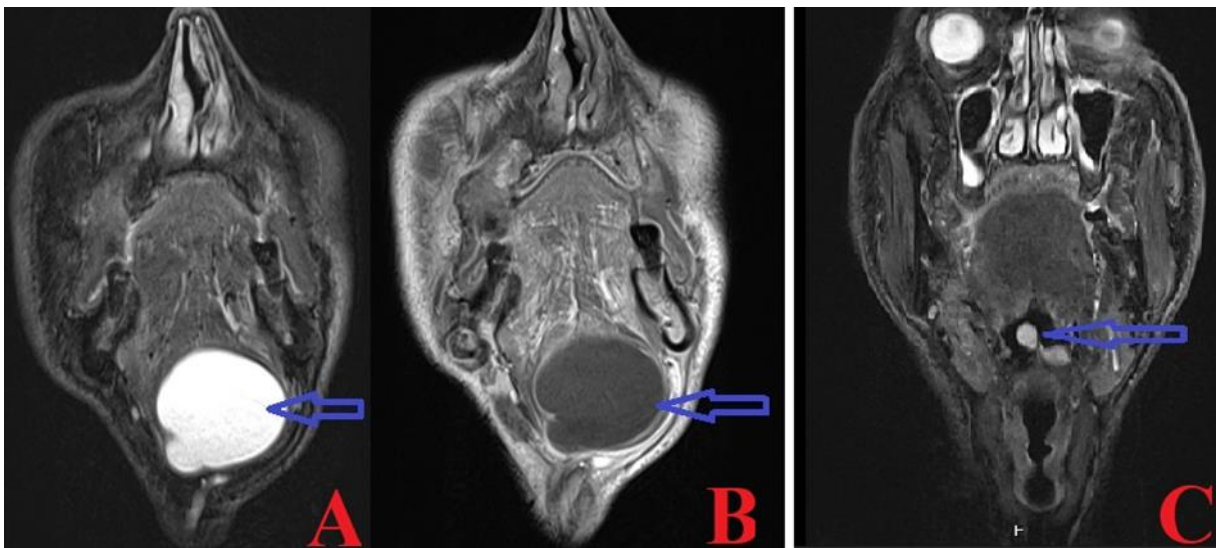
The coronal plane of the MRI shows a cystic mass (A, B) and valvular cysts (blue arrow) (C) in T2 (A), T1 (B), and T2 (C) sequences.
